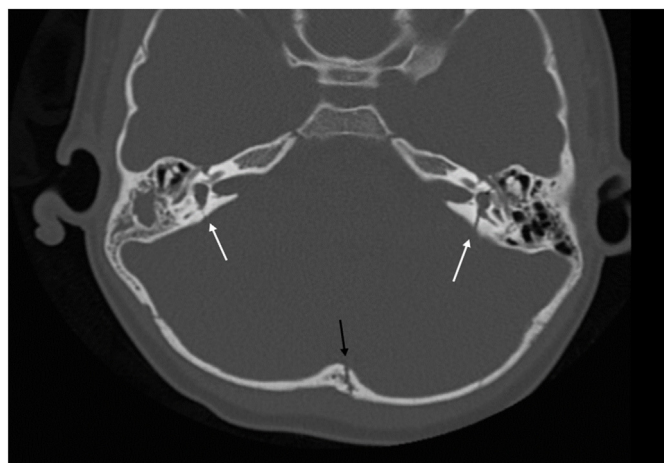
Injury to a 4-year-old child who fell from a height of less than 2 m. Axial image of computed tomographic scan shows an occipital fracture (black arrow) and a bilateral transverse fracture of the temporal bone (white arrows) with involvement of the otic capsule. Fluid is seen in mastoid air cells and tympanic cavities.
